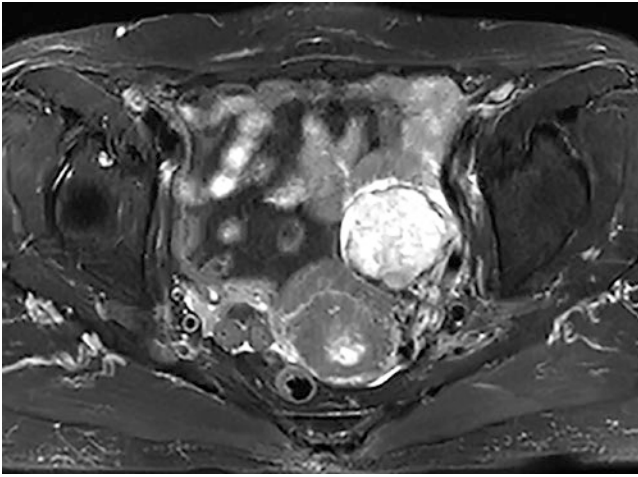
T2-weighted with fat suppression image showed the mass had high signal intensity
